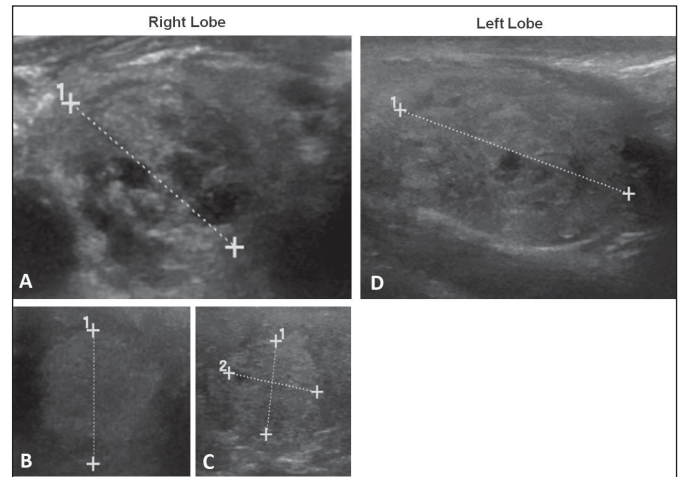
Thyroid ultrasound. Right Lobe: (A) 24 mm mixed predominantly solid isoechoic nodule; (B) and (C) 12 mm and 11 mm hyperechoic solid nodules. Left Lobe: (D) 33 mm mixed predominantly solid isoechoic nodule.
